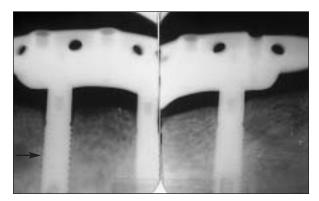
Radiographic analysis revealed a classically failed distal implant (arrow), with a thin radiolucent line around its surface.
